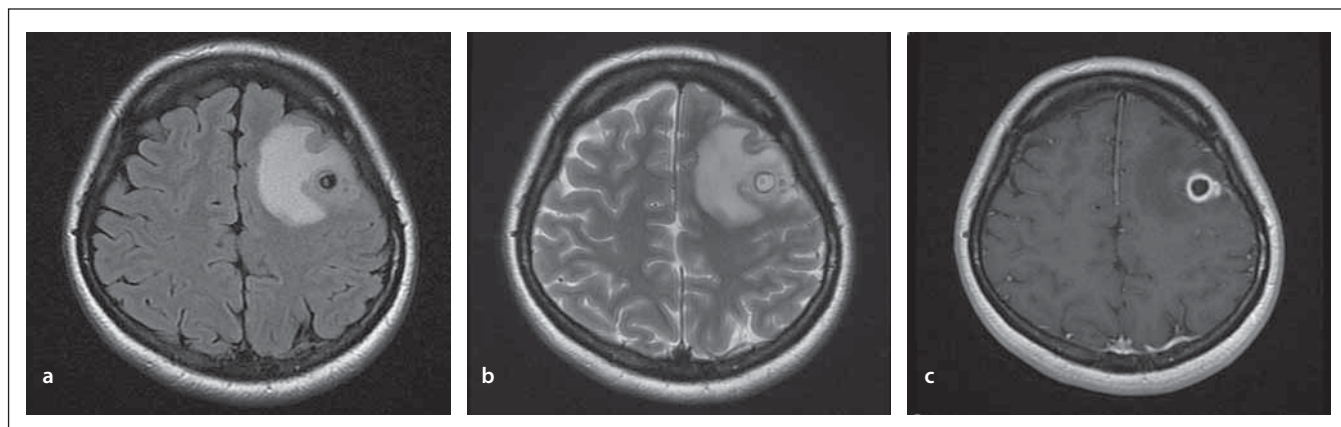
MRI of the brain, transversal images. Cystic ring enhancing lesion in the left frontal region, with distinct perifocal oedema; most likely a granular nodular stage of neurocysticercosis. (a) T1 weighted image; (b) T2 weighted image; (c) T1 weighted image with gadolinium.
